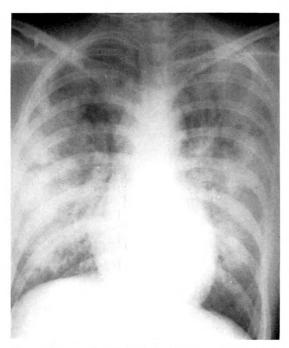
Case 1. Anteroposterior roentgenogram made with a portable unit approximately 24 hours after injury shows marked diffuse pulmonary density, slightly more marked in the lateral periphery of the lungs.
